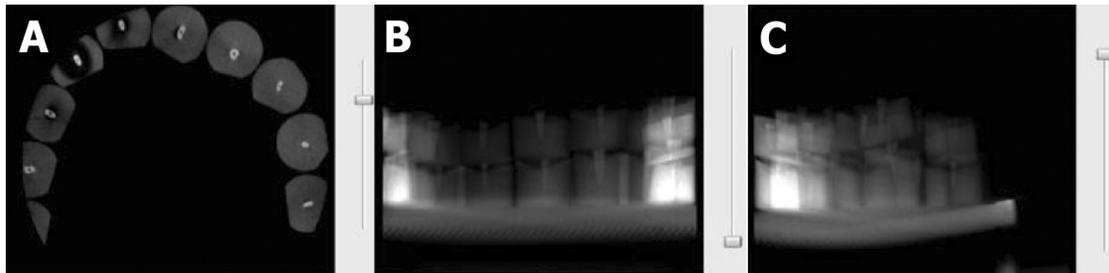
CBCT image of a ten-series of fractured and non-fractured teeth A) axial view, B) coronal view, and C) sagittal view
